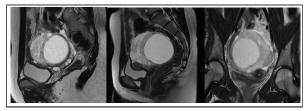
MRI Presentation of Massive Ovarian Edema
